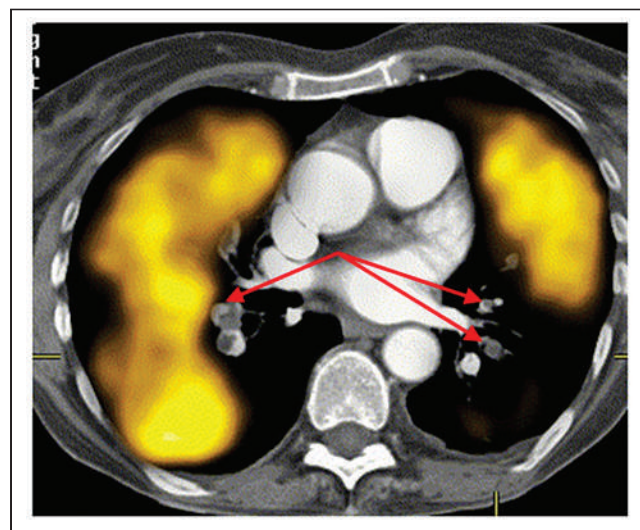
Fused perfusion SPECT and CTPA showing pulmonary emboli (arrows) bilaterally in arteries with associated perfusion defects on SPECT. (Reprinted with permission of (4).)
